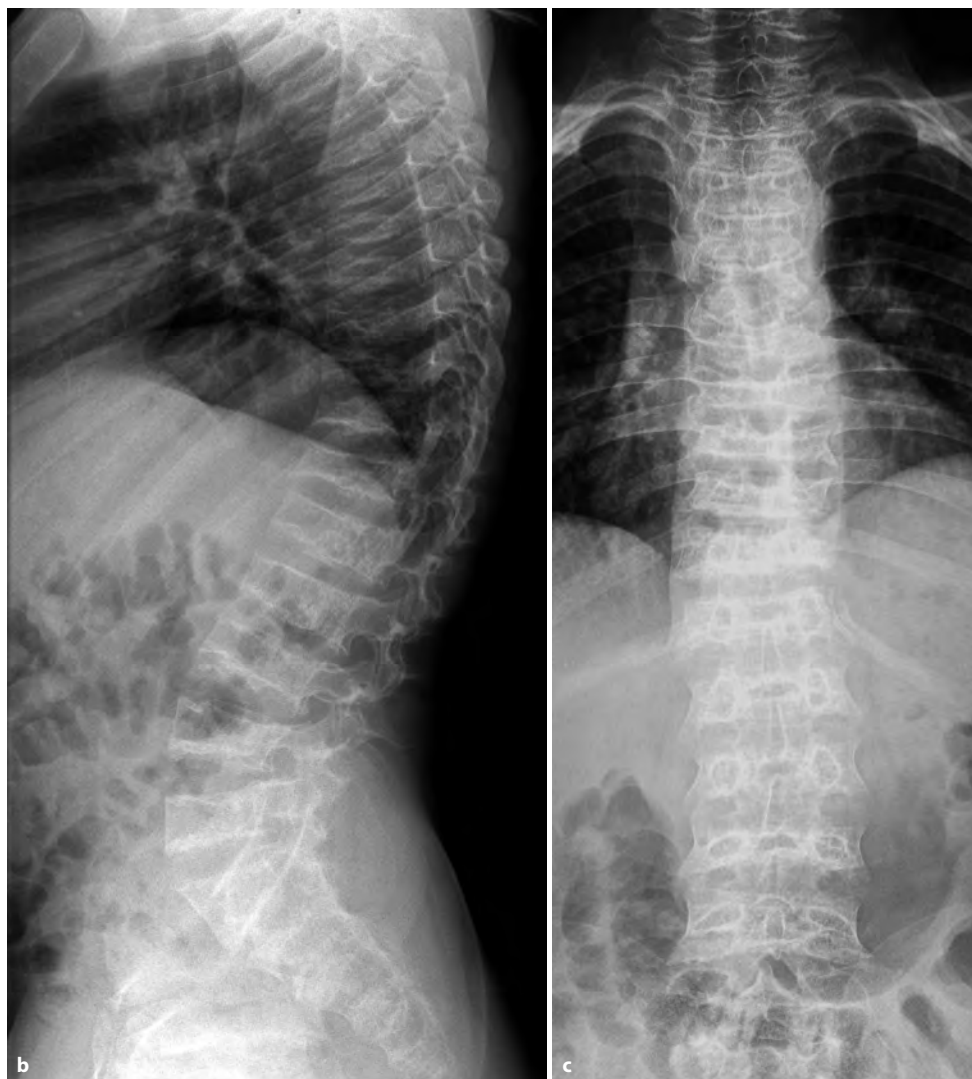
a–e: Radiographs of CASE I at 13 years of age: b, c: Long format spine AP and lateral projection: Thoracolumbar kyphosis and lumbar hyperlordosis. Platyspondyly with anterior wedging of the thoracic vertebrae. Note the additional bony buildup in the posterior two-thirds of the lower thoracic bodies and the upper lumbar spine
